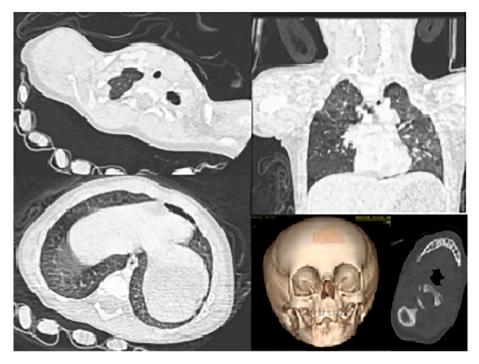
Left laminar pneumothorax and peripheral opacity in the lingula compatible with pulmonary contusion. The initial suspicion of skull base fracture was excluded on CT-SCAN.
